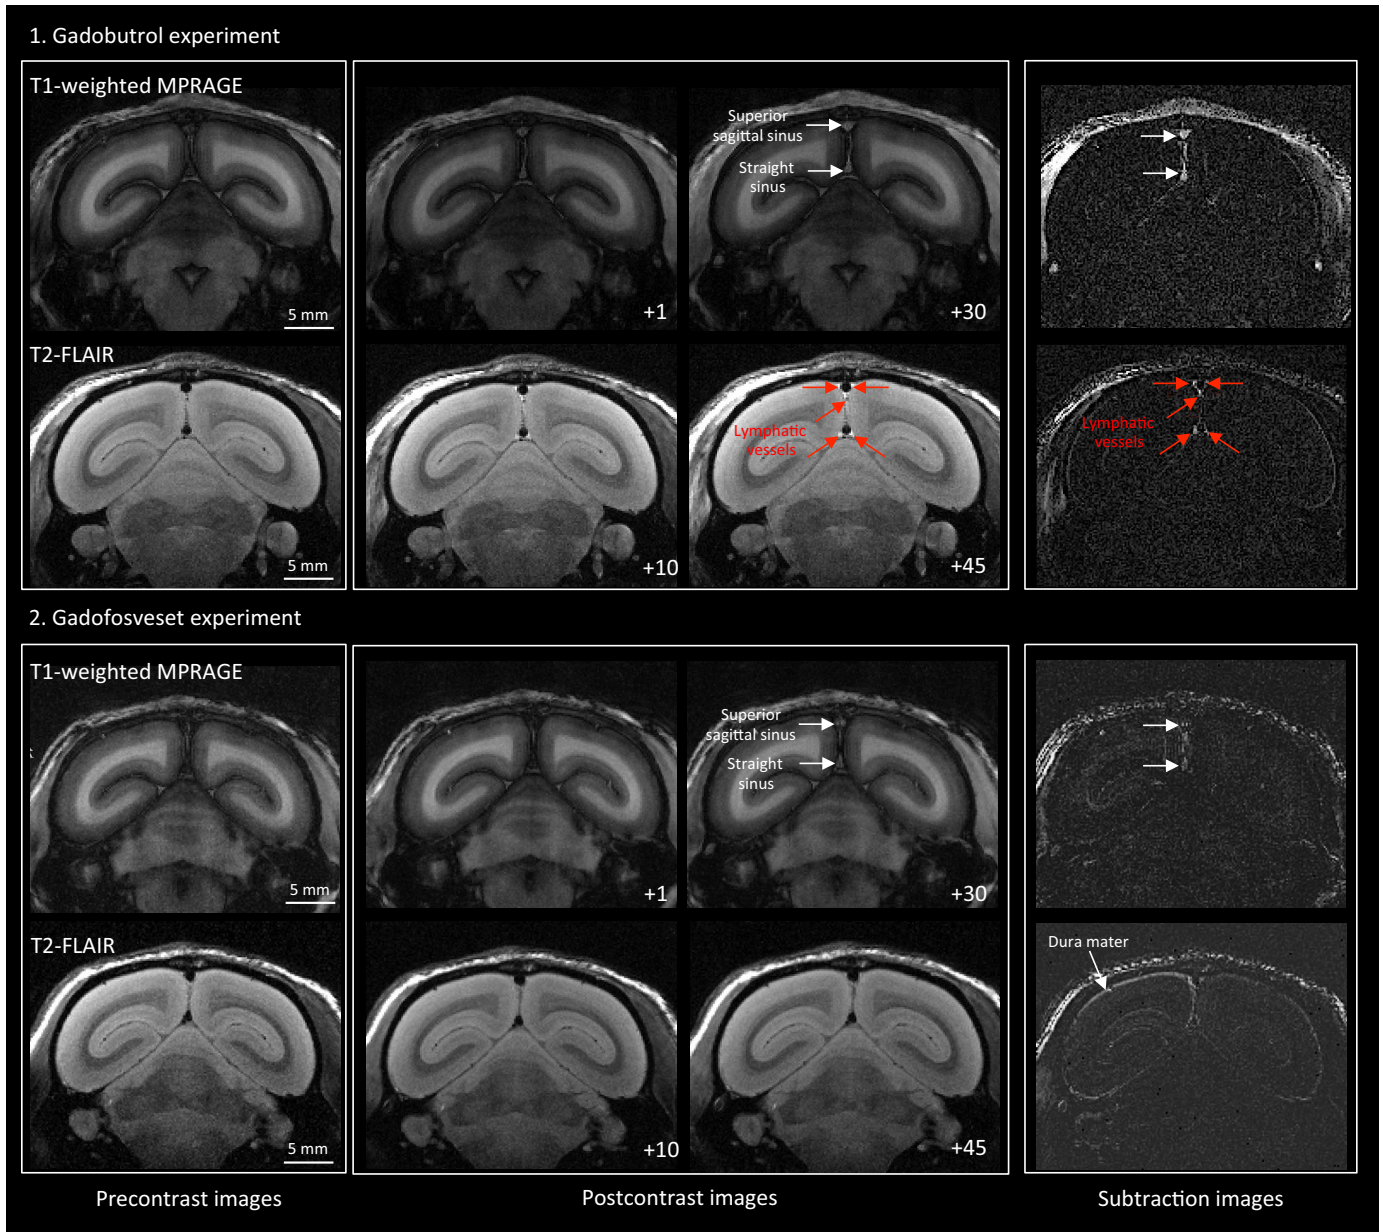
figure supplement 1. MRI visualization of dural lymphatic vessels in a healthy marmoset with different contrast agents. In an 11-year-old healthy common marmoset, high-resolution ($150 \times 150 \mu\text{m}$ in-plane) coronal T1-weighted MPAGE and T2-FLAIR were acquired before and at different time points after the injection of two different contrast agents (single dose of gadobutrol and gadofosveset), a week apart. (1) Gadobutrol experiment. Dural lymphatic vessels are discriminated on postcontrast T2-FLAIR and on subtraction images (post vs. precontrast images), but not on postcontrast 3D T1-weighted MPAGE. (2) Gadofosveset experiment. Gadofosveset, which binds serum albumin and therefore remains largely inside blood vessels (white arrows on postcontrast T1-MPAGE and subtraction images), even in tissues (such as the dura mater) that lack a blood-brain barrier, is FDA-approved for magnetic resonance angiography. Dural lymphatic vessels are not visible on post-gadofosveset T2-FLAIR and relative subtraction images, even on delayed acquisition (45 min after injection), despite preserved enhancement of the dural venous sinuses. Numbers refer to minutes after intravenous administration of the contrast agent.
